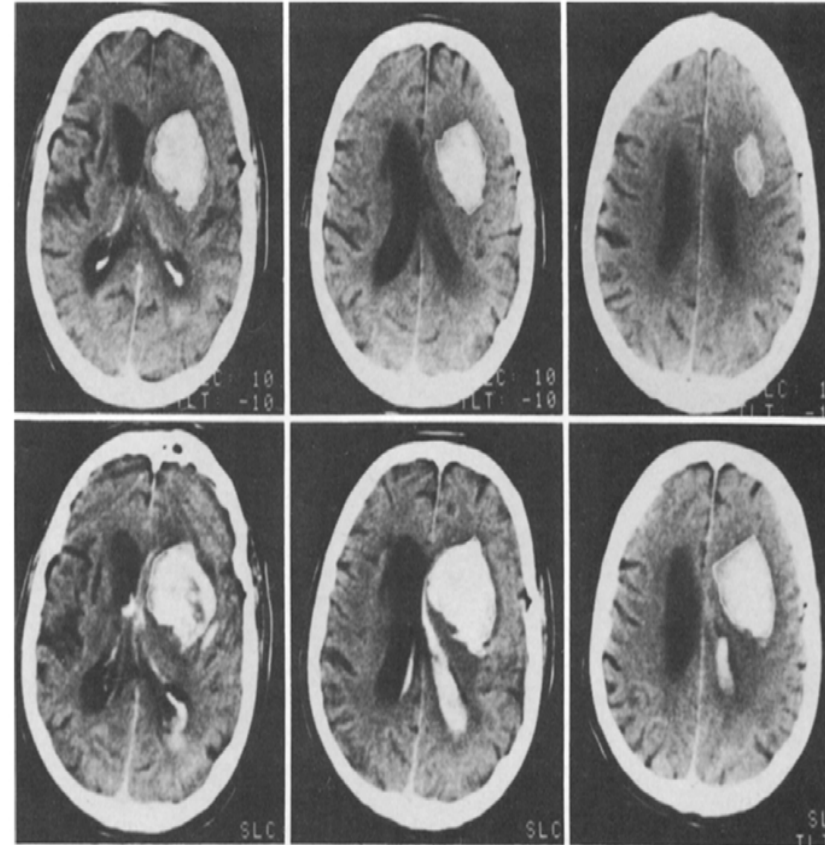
Serial computerized tomography (CT) scans in Case 1. Measurement of the volume of hemorrhage revealed an increase from 25 to 44 cc between the first CT scans (*upper*), obtained 35 minutes after onset of symptoms, and the second CT scans (*lower*), obtained 105 minutes after onset.
